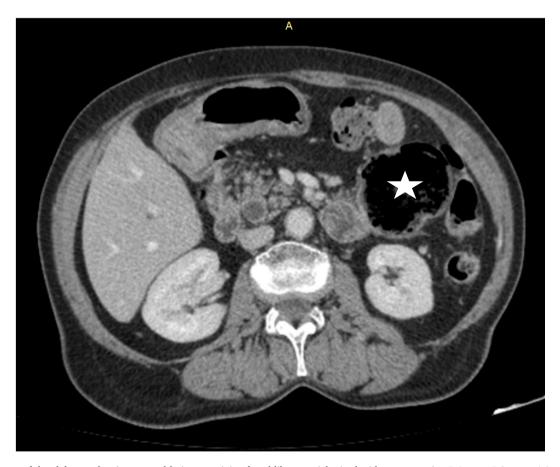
The CT-scan of the abdomen showing a round lesion containing faecal-like material mixed with gas measuring 5.4 cm \times 5.8 cm \times 4.6 cm depending on the jejunum.
